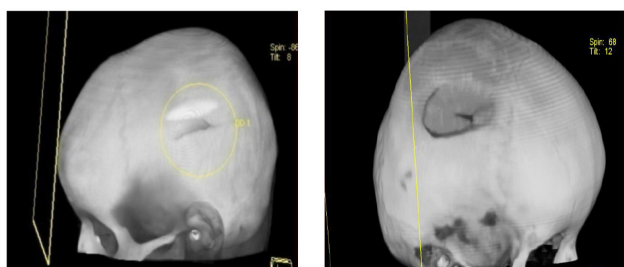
3D CT scan showing a left (picture on the left) and a right (picture on the right) parietal compound depressed fracture of two different children both of them had sustained fan injury.
